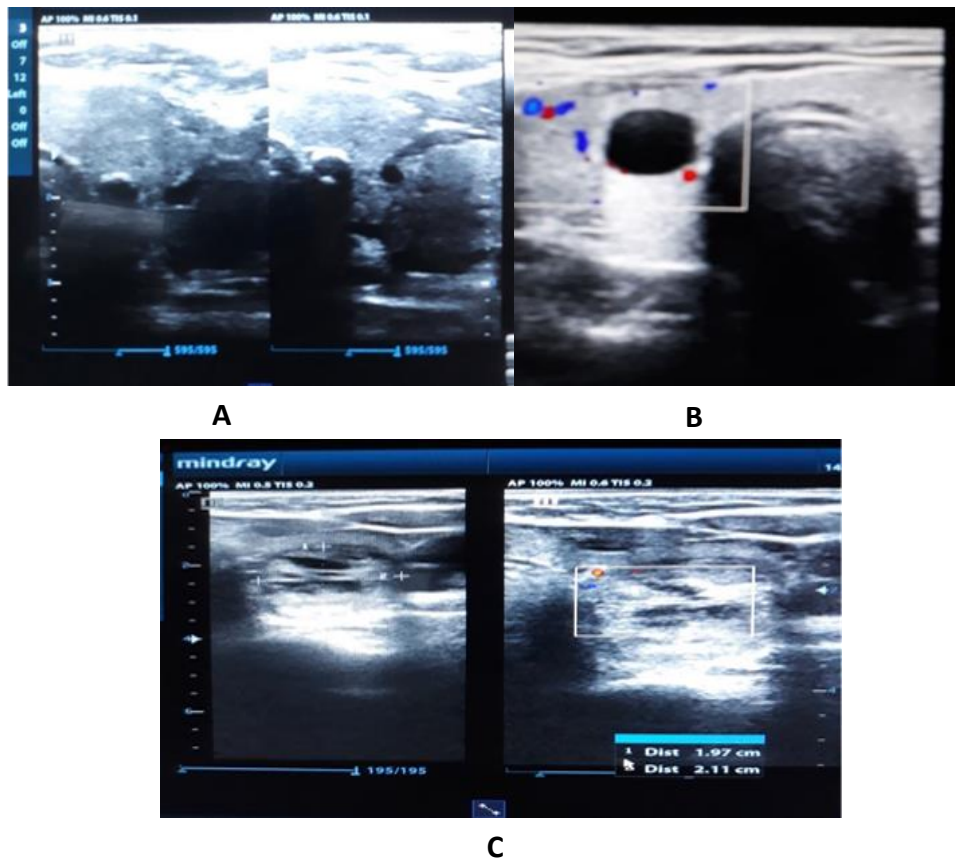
Ultrasound features of TI-RADS 2 nodule: A: simple cystic thyroid lesion
